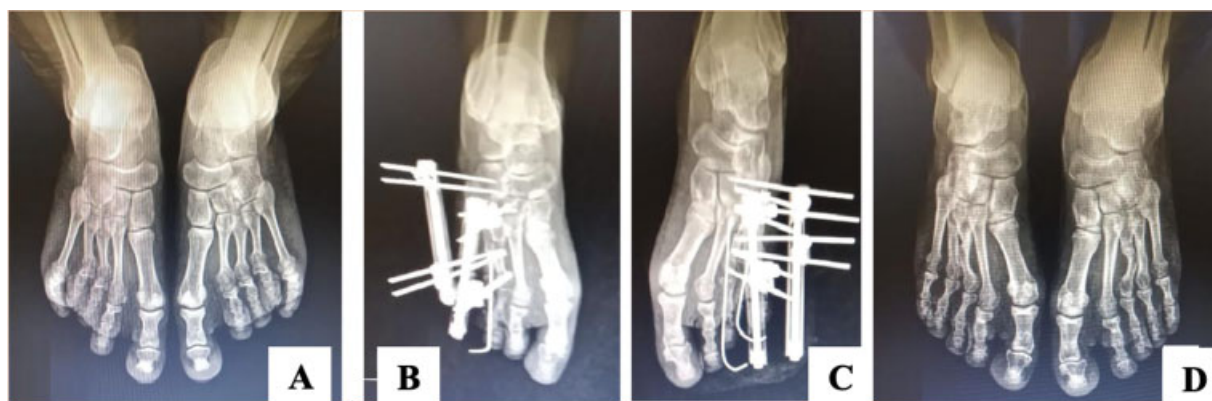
Radiograph in anteroposterior incidence of the feet with load demonstrating the evolution of a patient with bilateral brachymetatarsia in the 3rd and 4th metatarsi submitted to osteogenic distraction. (A) preoperative radiography, (B) postoperative radiography of the right side, (C) postoperative radiography of the left side; and (D) result after 12 weeks of treatment.
